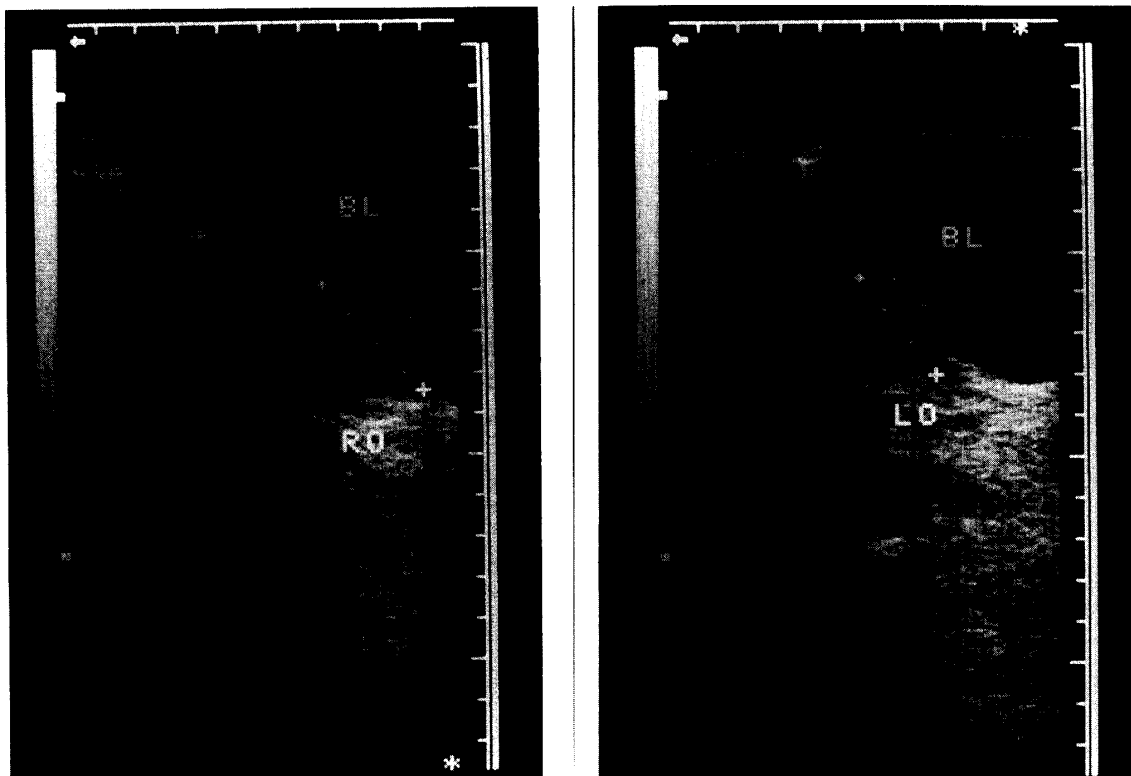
Ultrasonograms of peripheral (LO; left ovary) and general cystic ovaries (RO; right ovary) in Case 10. BL; bladder.
